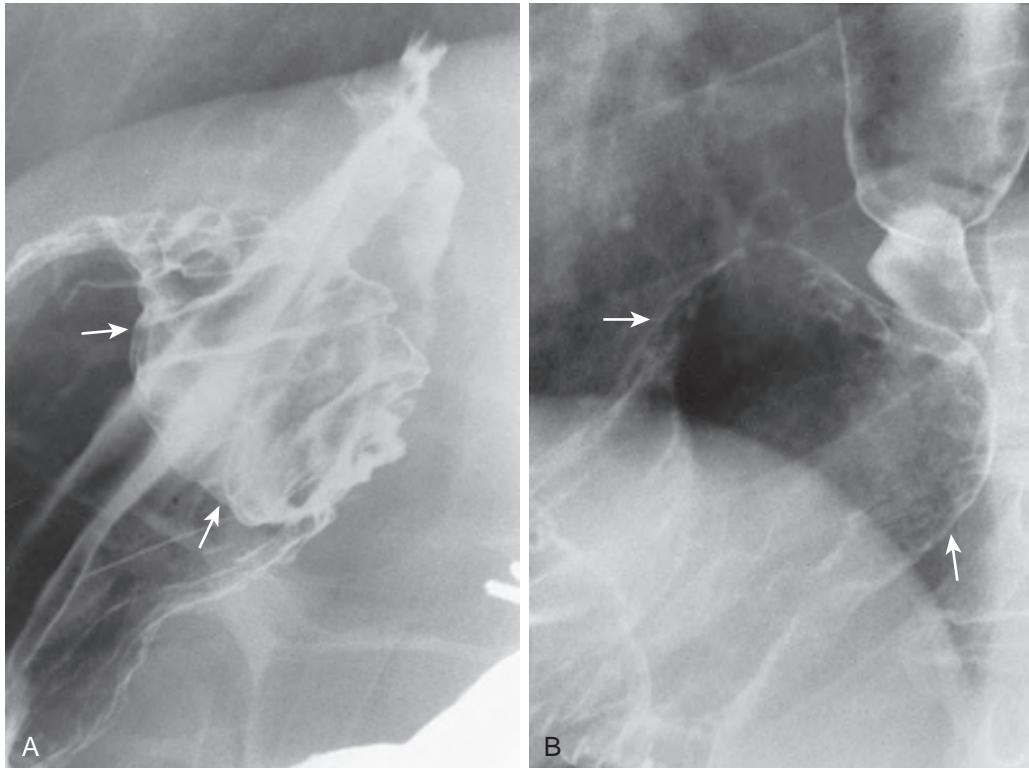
Pseudotumor in the gastric fundus caused by an invaginated hiatal hernia. A. An apparent mass lesion (arrows) is seen in the fundus on a double-contrast radiograph. B. Moments later, the invaginated hernia (arrows) has risen above the diaphragm, and the pseudotumor is no longer seen.
